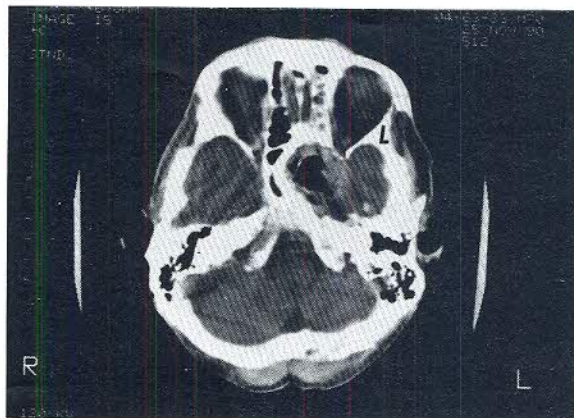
Case 4. CT scan (with IV contrast) taken 2 weeks postoperatively shows a minimal residual collection of mucinous material in the mucocoele cavity (note that the right/left scanner notation is the reverse of the notation used in Figure 4a).
